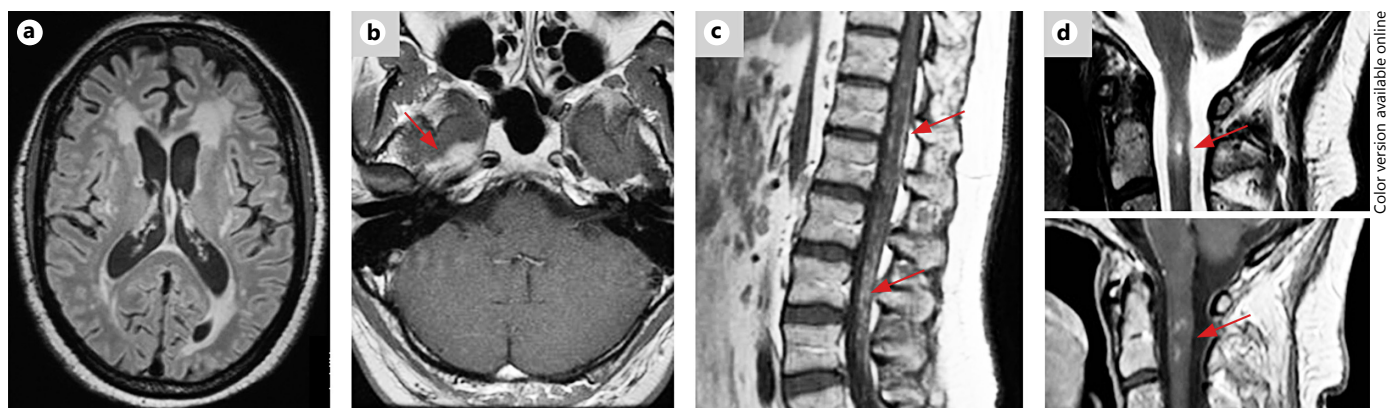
Neurosarcoidosis imaging patterns. Characteristic MRI findings in neurosarcoidosis patients: (a) T2/ FLAIR hyperintensities without contrast enhancement, (b) brain solitary, contrast enhancing
